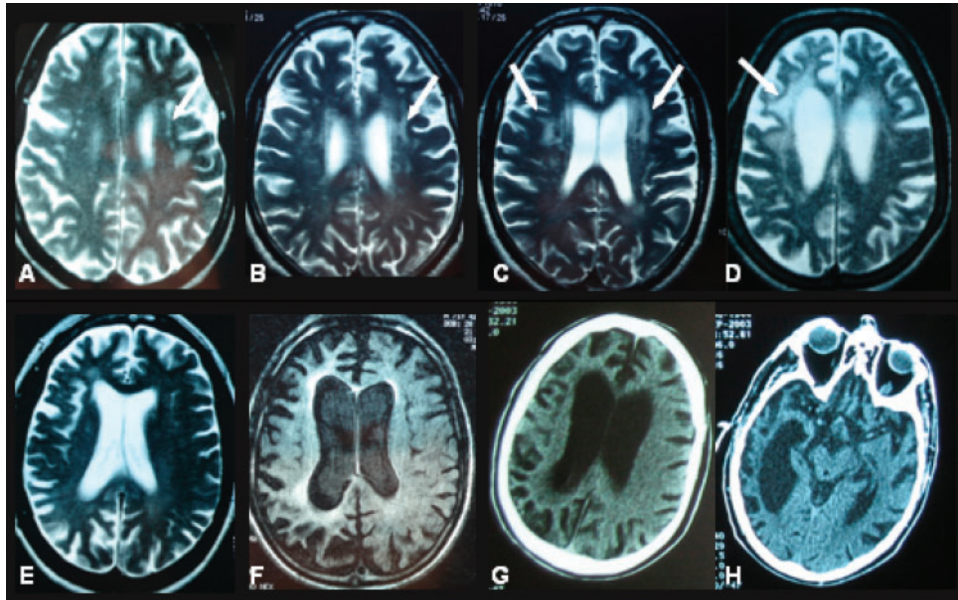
Brain MRI T2 (A–E) and T1 (F) sequences and CT scan (G, H) in *GRN* mutation carriers. (A–D) Moderate to marked white matter lesions (arrows). (E–H) Clear asymmetric and posterior atrophy.
